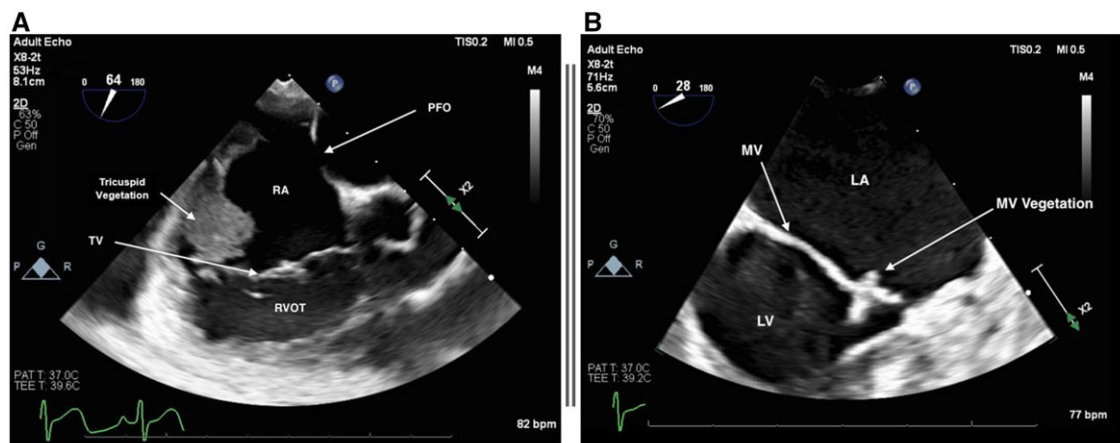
(A) Transoesophageal echocardiogram showing a large vegetation measuring 2.8 cm × 0.9 cm attached to the atrial side of a posterior tricuspid leaflet with a patent foramen ovale. (B) Transoesophageal echocardiogram showing a small vegetation measuring 0.3 cm × 0.6 cm attached to the anterior mitral leaflet.
